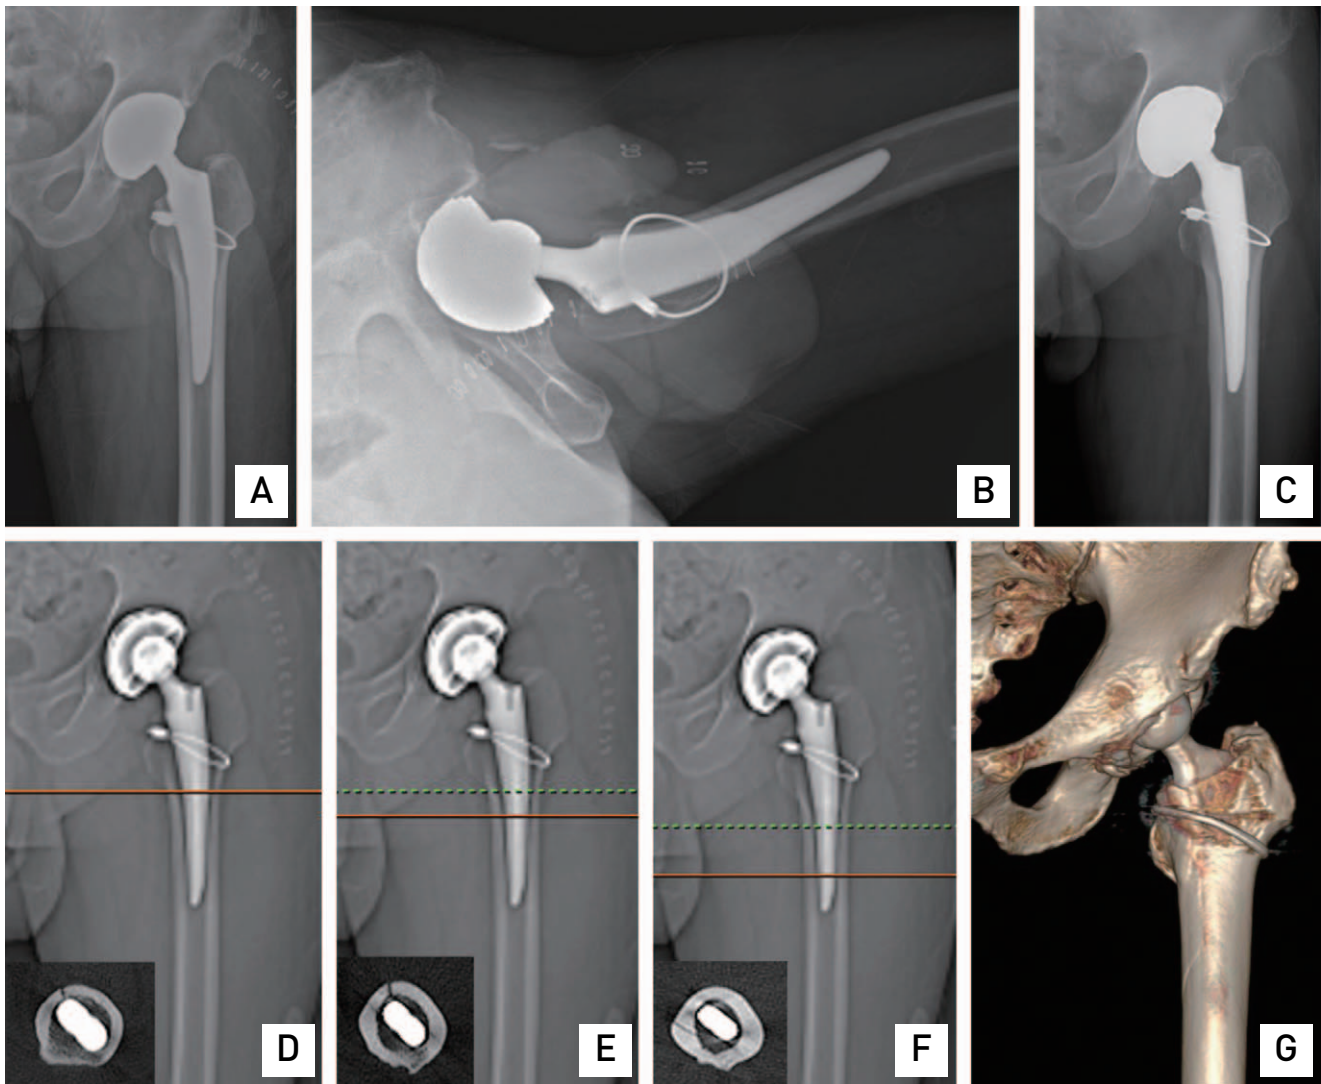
A 71-year-old male who underwent total hip arthroplasty using a Tri-lock® stem. (A, B) Immediate postoperative radiograph. A type TL periprosthetic femoral fracture was detected during the operation and fixed by cerclage wiring. (C) Three-year postoperative radiograph showed no abnormal findings in the left hip. (D-F) Immediate computed tomography (CT) images. (G) A periprosthetic occult femoral fracture that extended to the tip of the femoral stem was observed concurrently on axial and three-dimensional CT reconstruction images at different levels.
